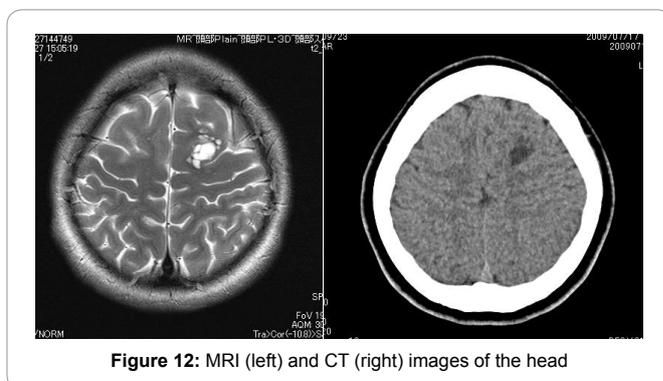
MRI (left) and CT (right) images of the head
